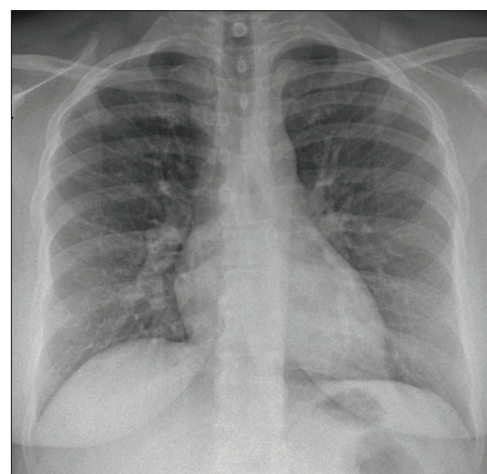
Chest X-ray showing bilateral mid and lower zone haziness (Case 3)
